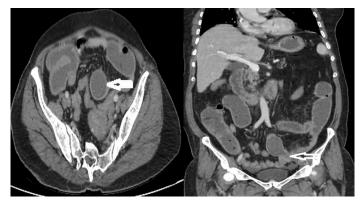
The image of obstruction site and stone causing obstruction in the computed tomography
